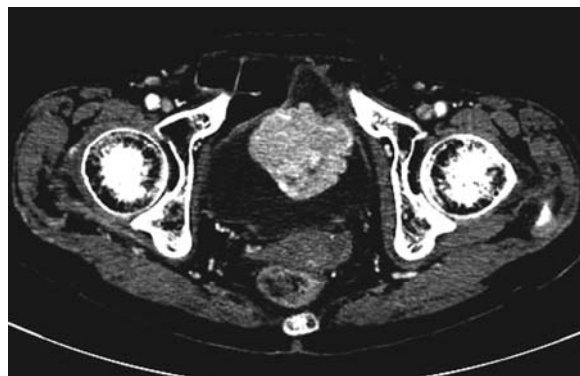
Computerized tomography (CT) scan shows a contrast-enhanced mass on the anterior wall of the urinary bladder.
